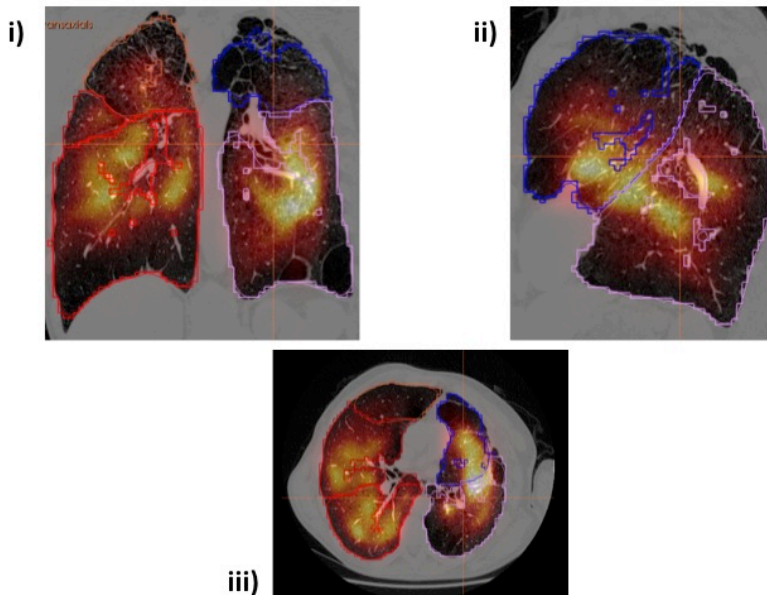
Selected images of NM-Q SPECT/CT acquired from OXF0139. Images are in the i) coronal, ii) sagittal and iii) axial plane.
